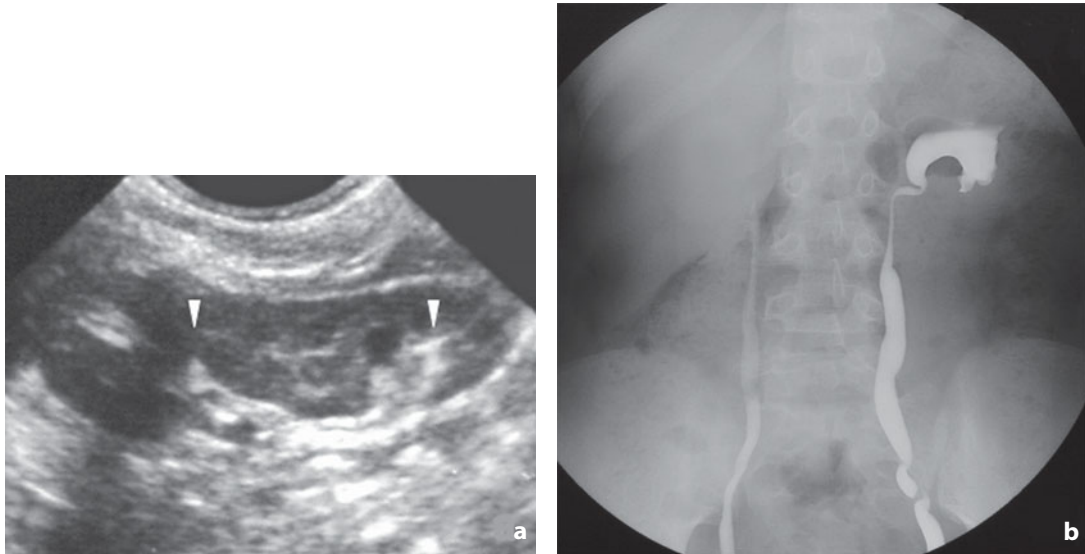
Duplex collecting system. a Longitudinal sonogram shows the separation of the central pelvicaliceal system (*arrowheads*) into an upper and lower pole collecting systems. b Voiding cystourethrography demonstrates bilateral vesicoureteric reflux with enhancement of the lower pole moiety in the left kidney characterized by an overall reduction in the number of calices
